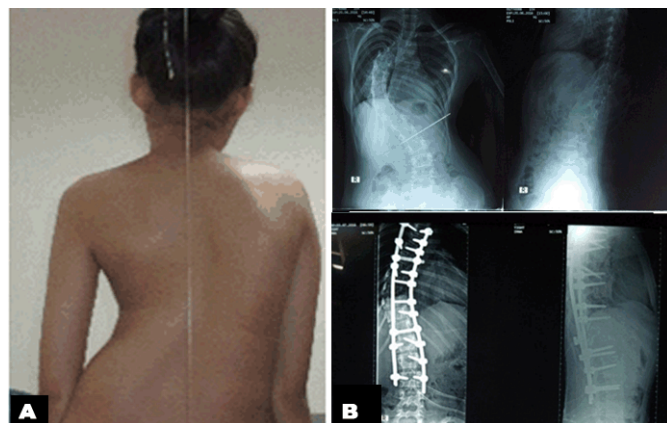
(A and B): Fourth patient case presentation: clinical picture pre-operative (A) and X-ray (B) pre- and post-operative.
